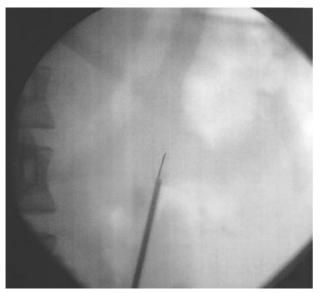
Transluminal puncture under ultrasound guidance is performed using the stiff end of the guide-wire.
